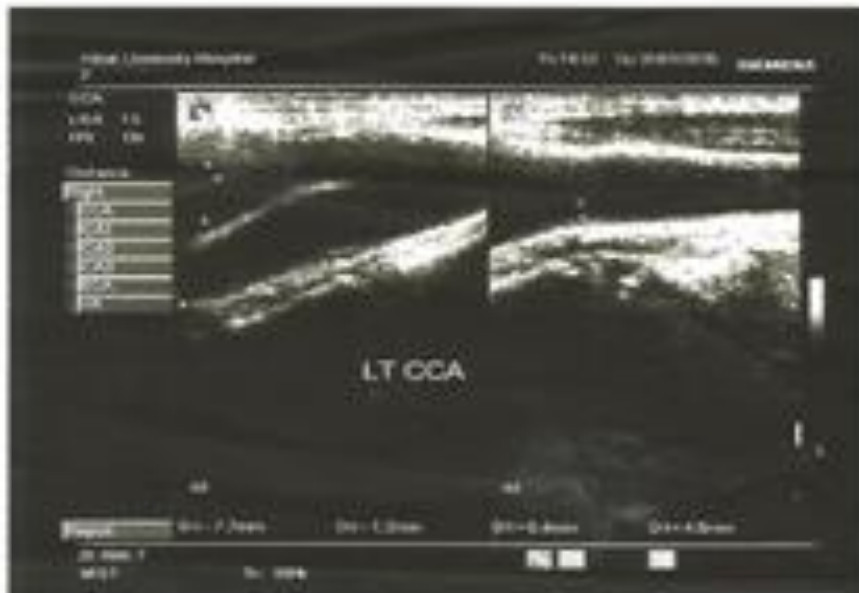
Lt CCA-female- 58 years diabetic patient with normal Doppler parameters.
